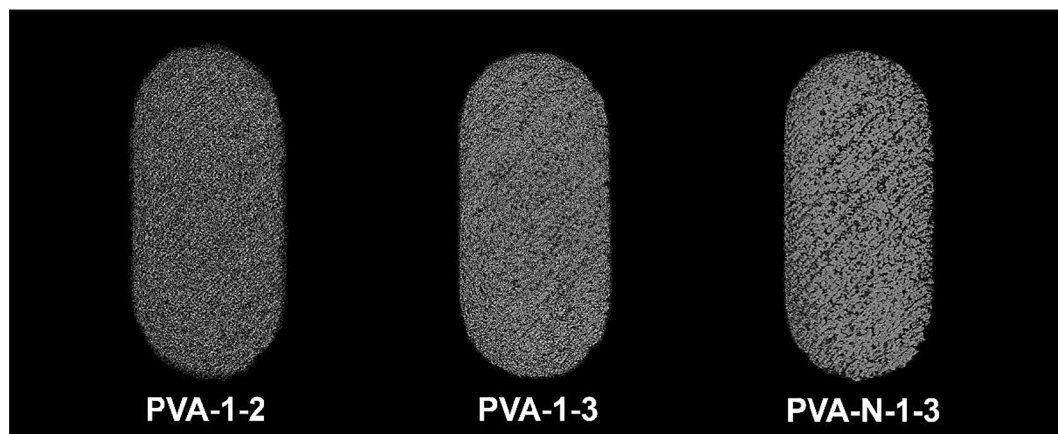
$\mu$ CT images of placebo and naproxen-loaded PVA-based tablets containing 1 wt% AC and printed at LPRs of 2 and 3.
